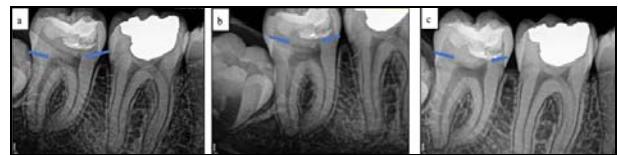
periapical radiographs at 3 periods follow-ups (a: after 3 months, b: after 6 months, c: after 12 months).
